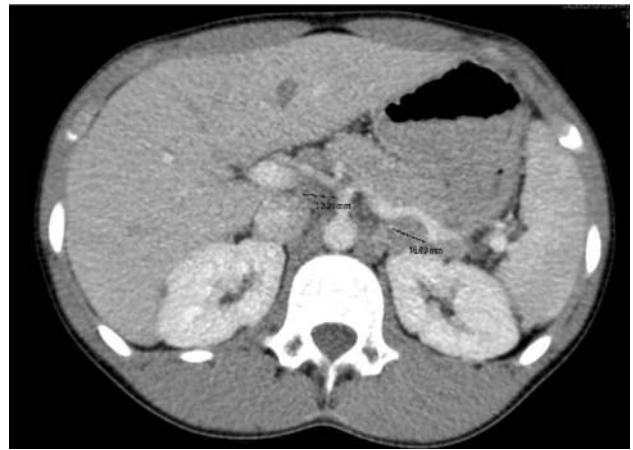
CT scan showing two coelio-mesenteric nodules due to recurrent SPT
